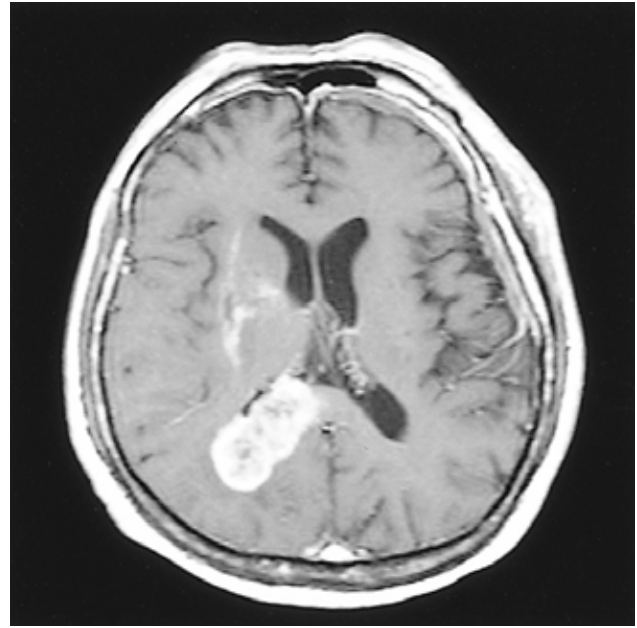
The brain MRI shows residual hematoma in the right basal ganglia and an additional mass lesion in the splenium portion of the right corpus callosum.
